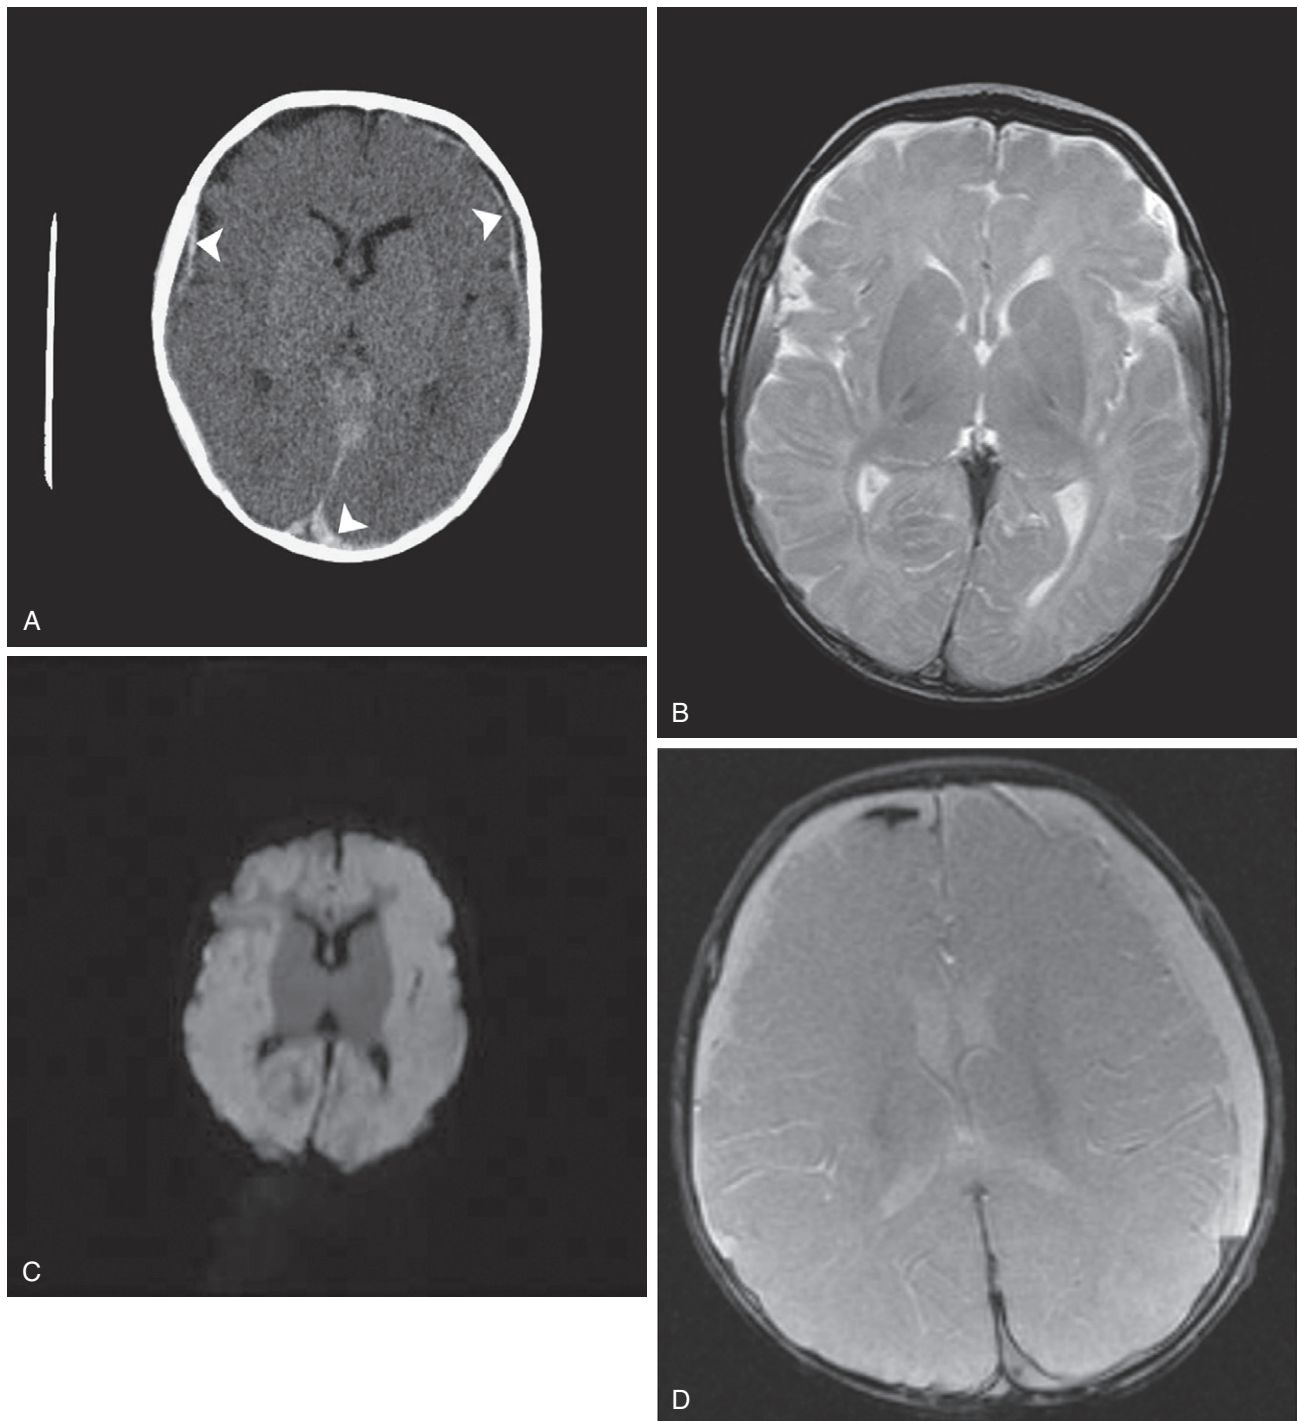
Nonaccidental trauma with diffuse cerebral ischemia. Axial noncontrast CT (A), axial T2-weighted (B), and diffusion-weighted MRI (C). A, CT shows a thin layer of acute subdural blood (*arrowheads*) and diffuse loss of gray-white demarcation in the cerebral hemispheres. B, Although the T2 image appears remarkably normal with appropriate lack of myelination in this 3-month-old child, the relative brightness of the cerebral hemispheres compared with the central gray on diffusion-weighted images (C) is consistent with a diffuse ischemic insult. D, Gradient-recalled echo MRI in another 4-month-old with nonaccidental trauma demonstrates dark, low signal areas in the right frontal subdural space and left posterior parafalcine regions, consistent with subdural hematomas.
